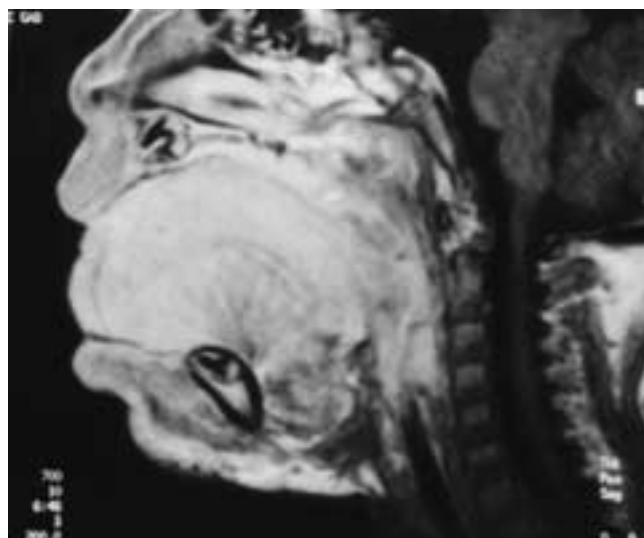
Sagittal postcontrast T1-weighted image shows diffuse enhancement and enlargement of the tongue due to a vascular malformation.
